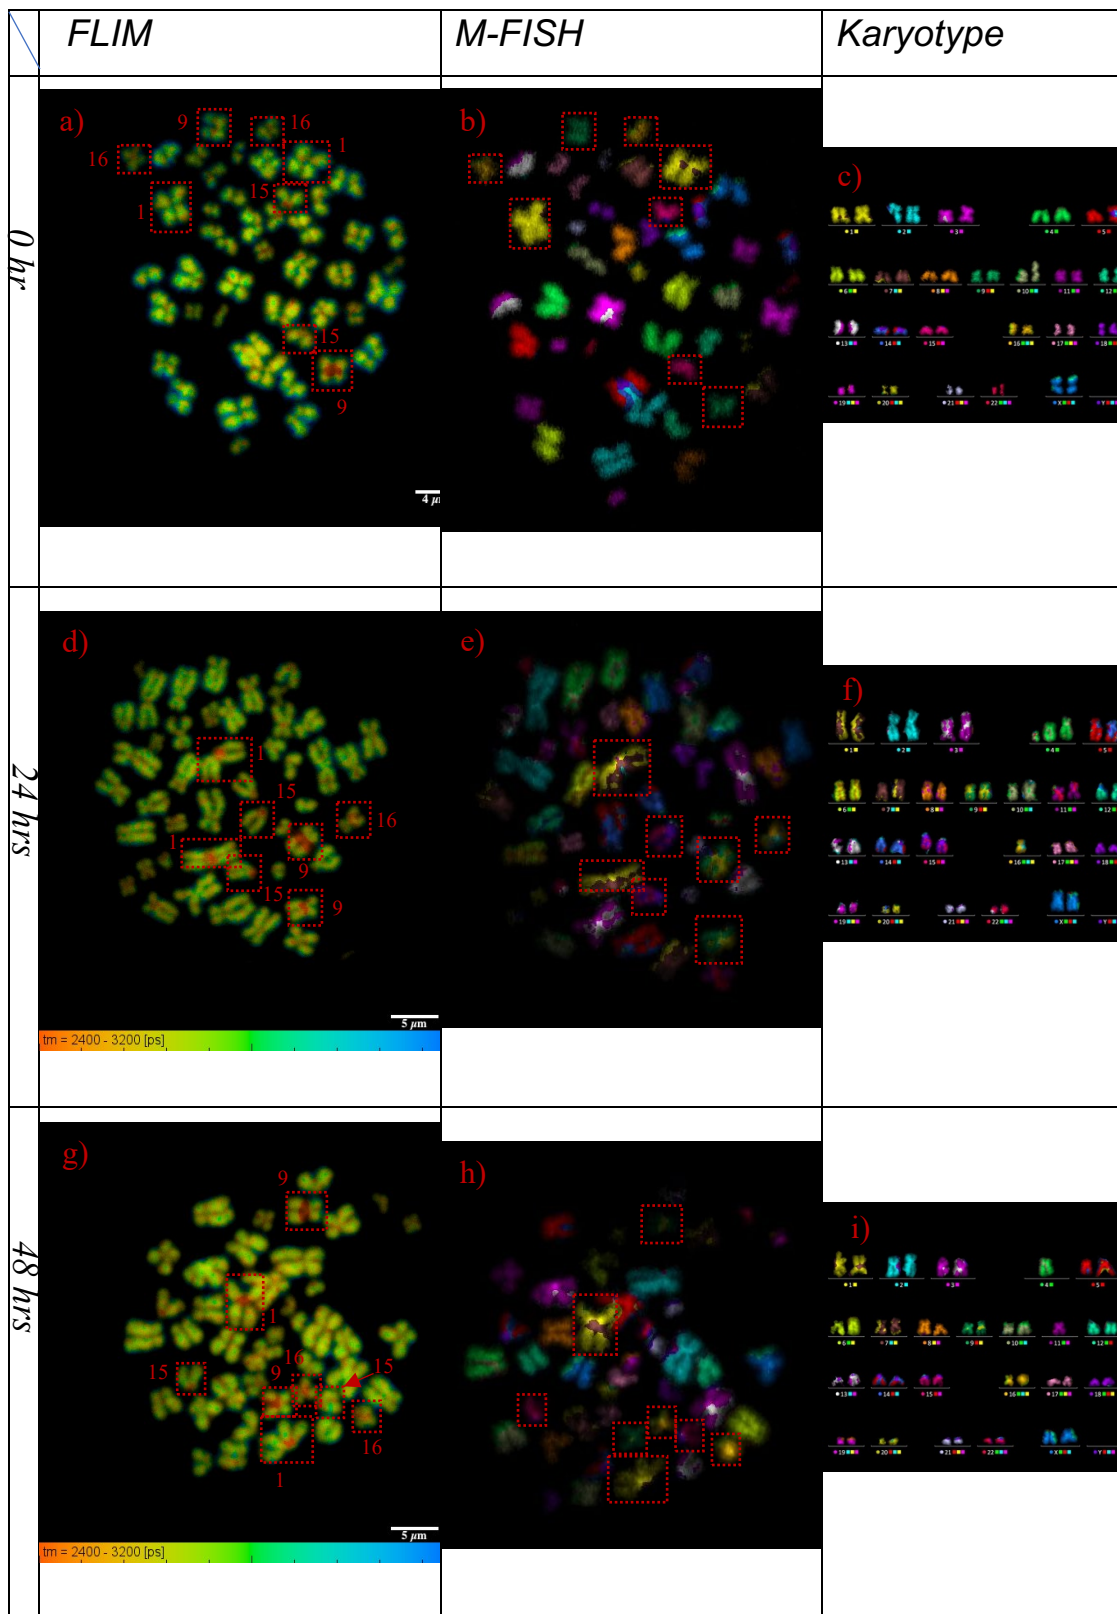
X-ray irradiated chromosome spreads from three different generations, irradiated at the rate of a 0.5 Gy/min. It represents the DAPI lifetime maps of each spread imaged using FLIM and with their corresponding M-FISH images and karyotypes. The row defines the three generations and column defines the imaging techniques and the karyotype. Figure a), d) and g) are the FLIM images; b), e) and h)
